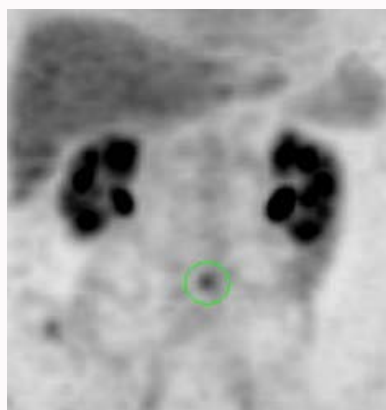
PET-FDG: abdominal uptake of the tracer.
